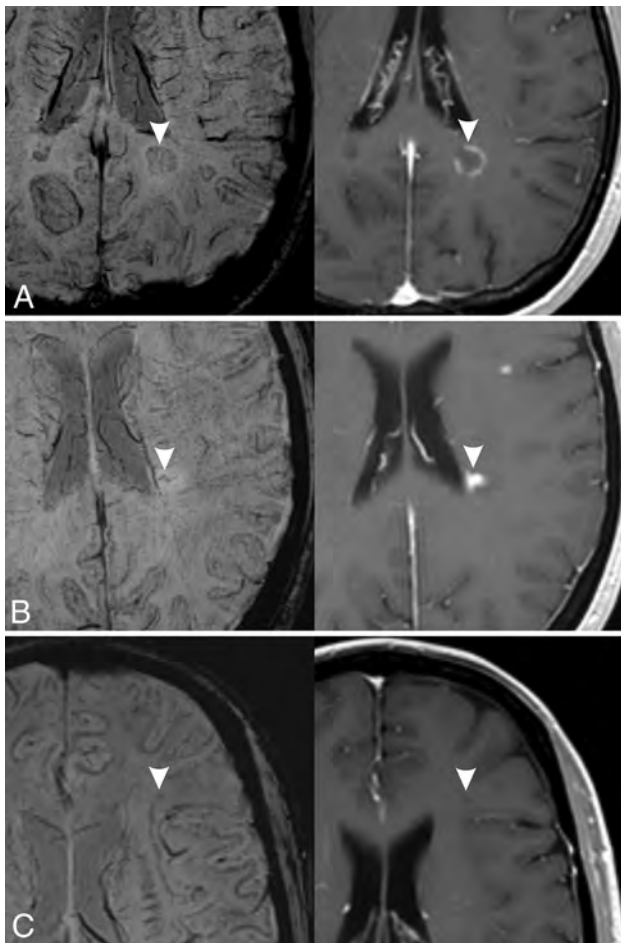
Exceptions to the associations found in our study. Three different MS lesions (arrowheads) are shown (left, SWI; right, contrast-enhanced T1-weighted image). A, Hypointense ring pattern on SWI with enhancement in postcontrast image. B, Marked hypointensity pattern on SWI (irregular dots) with enhancement in postcontrast image. C, Mild hypointensity pattern on SWI without enhancement in postcontrast T1-weighted image.
